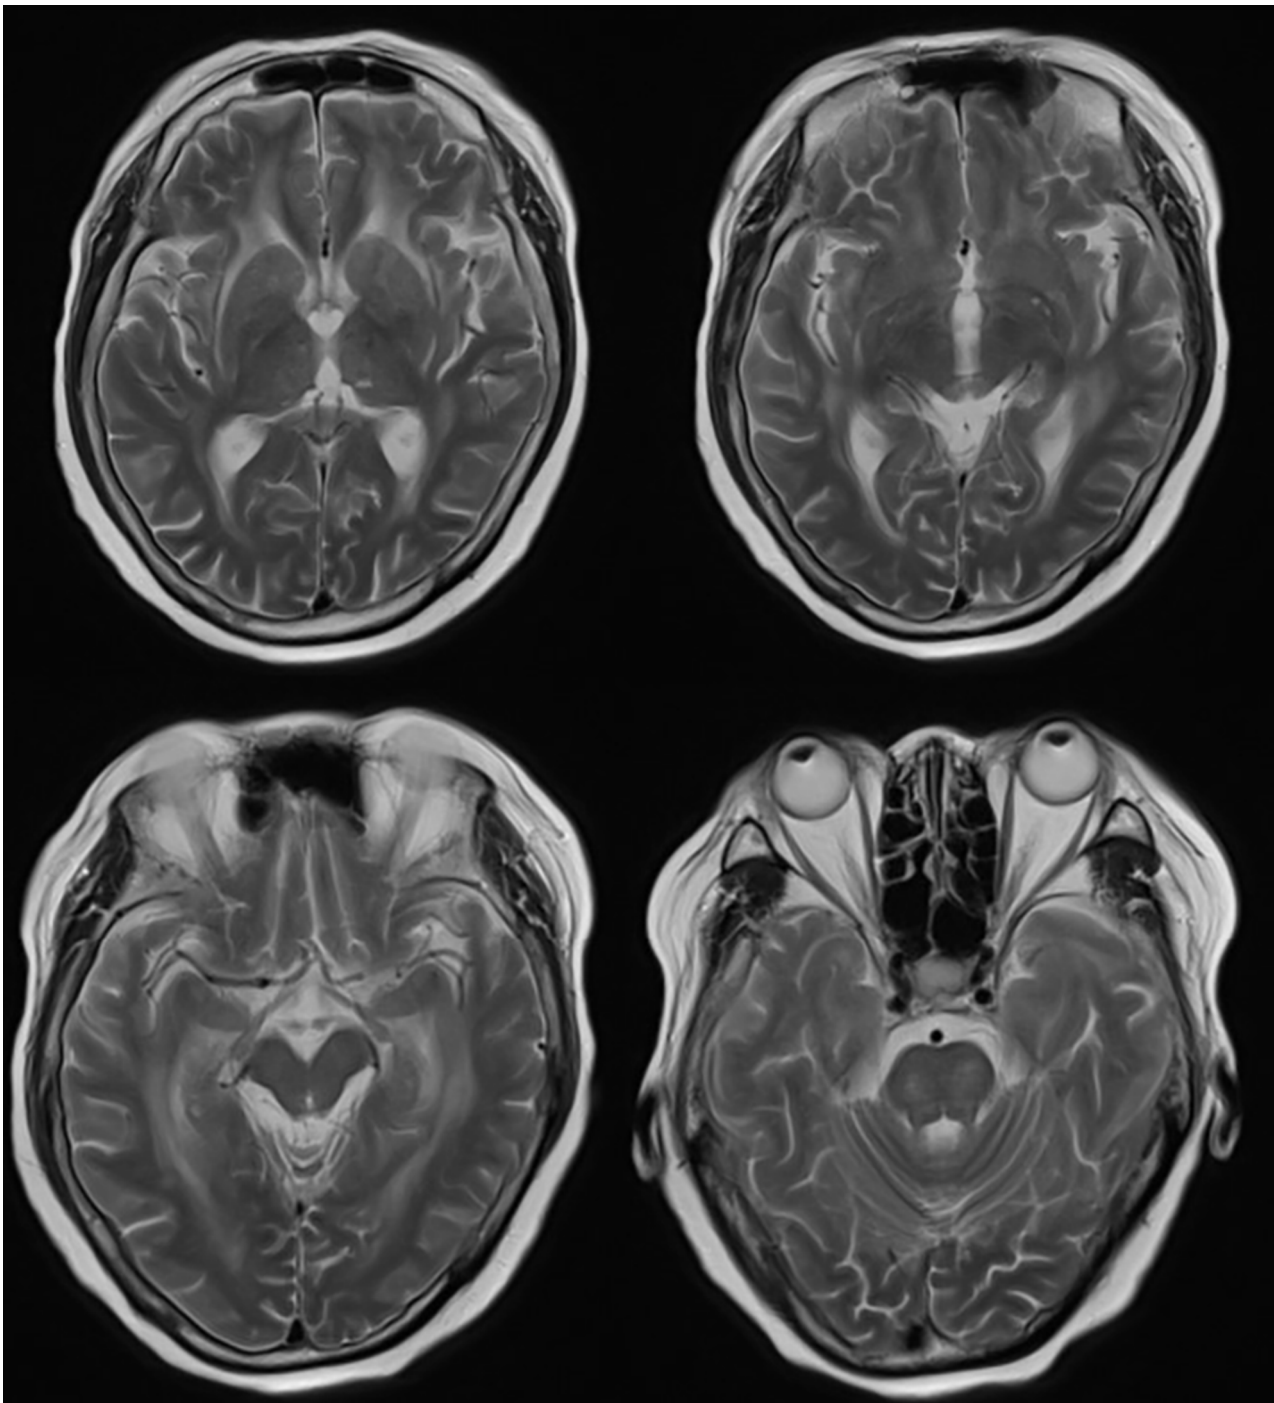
Head MRI plain scan +DWI showed no evidence of infection
